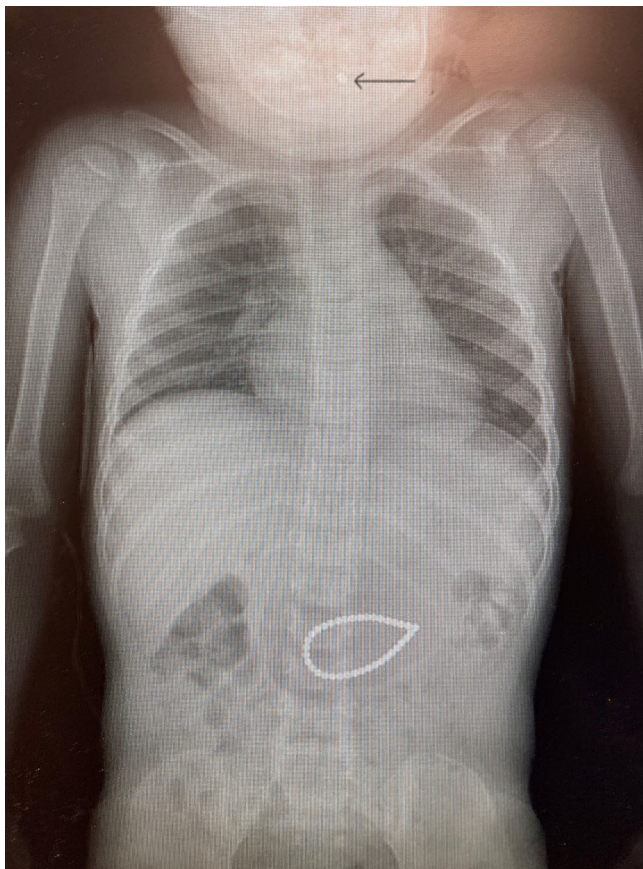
X-ray of chest and abdomen
